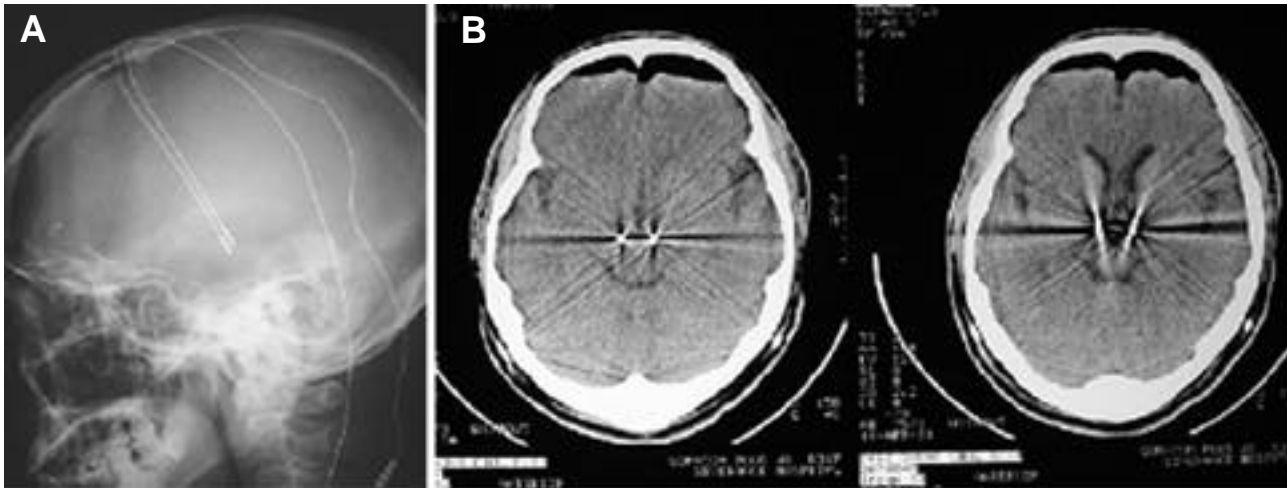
Chronic bilateral subthalamic DBS for idiopathic Parkinson's disease. Skull lateral view (A) and brain CT scan (B) demonstrate the bilateral electrode in the subthalamus of the brain.
